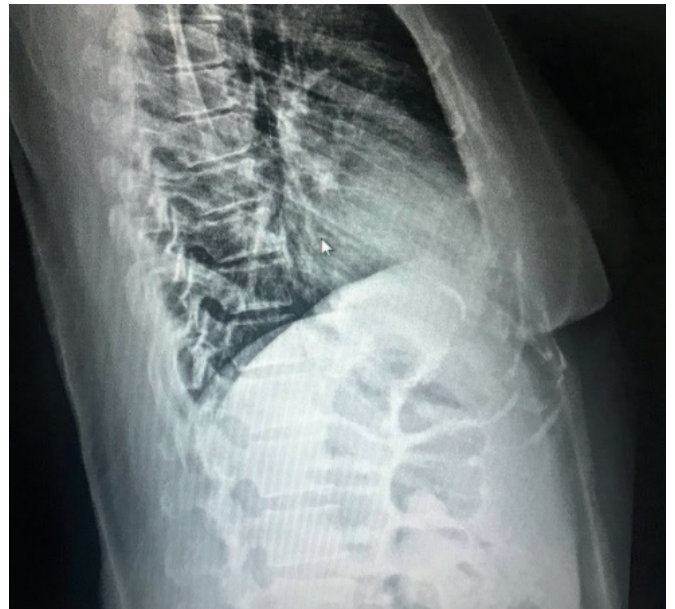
Radiograph of the dorsal spine.
